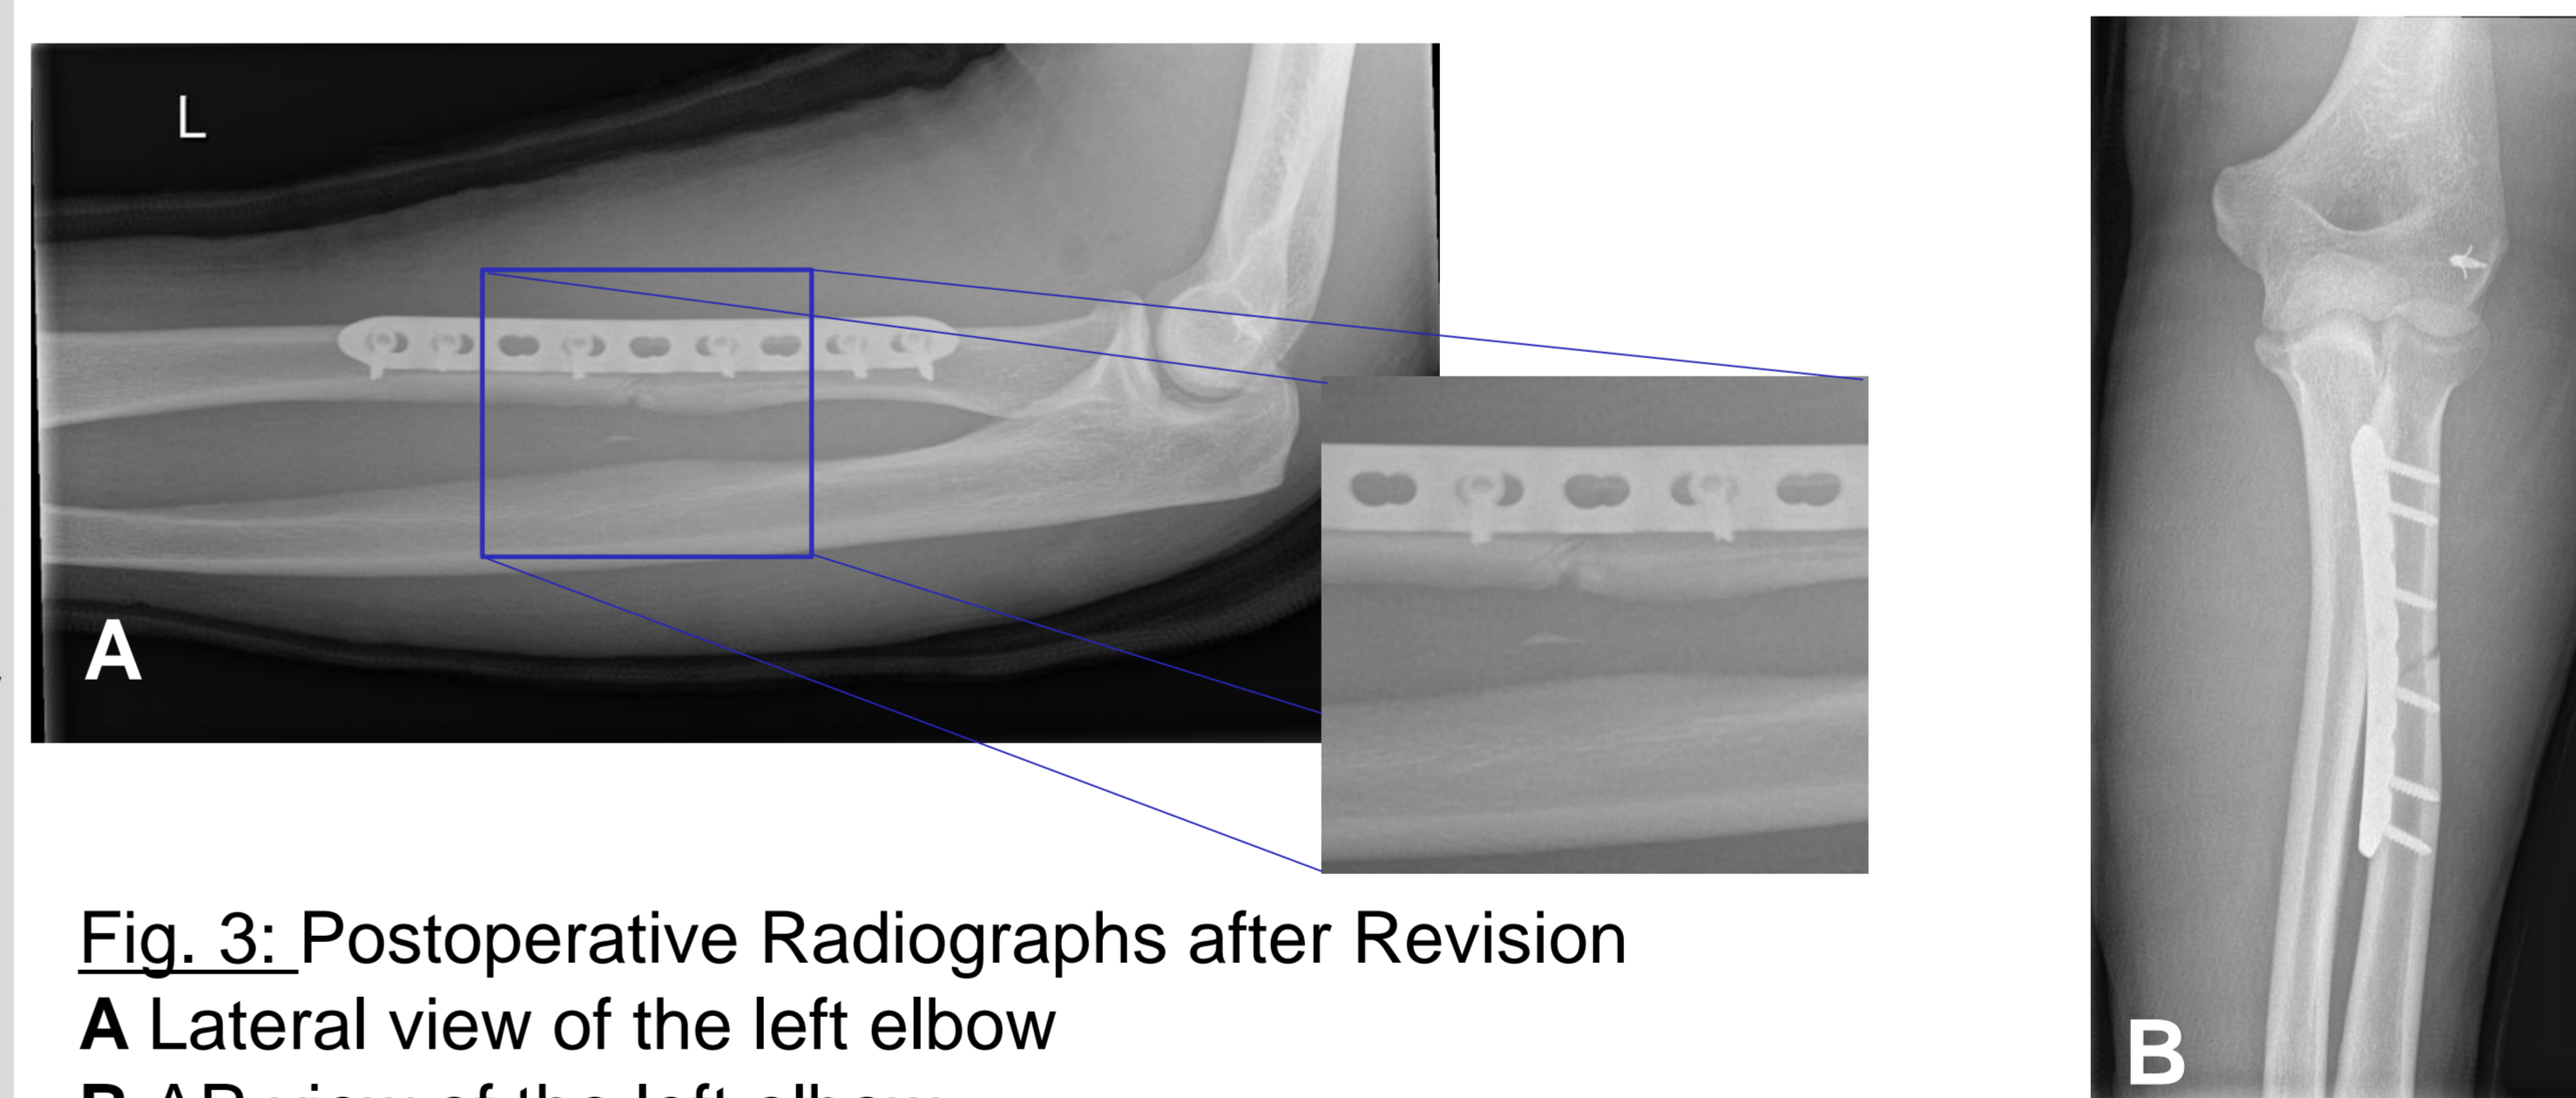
Postoperative Radiographs after Revision
